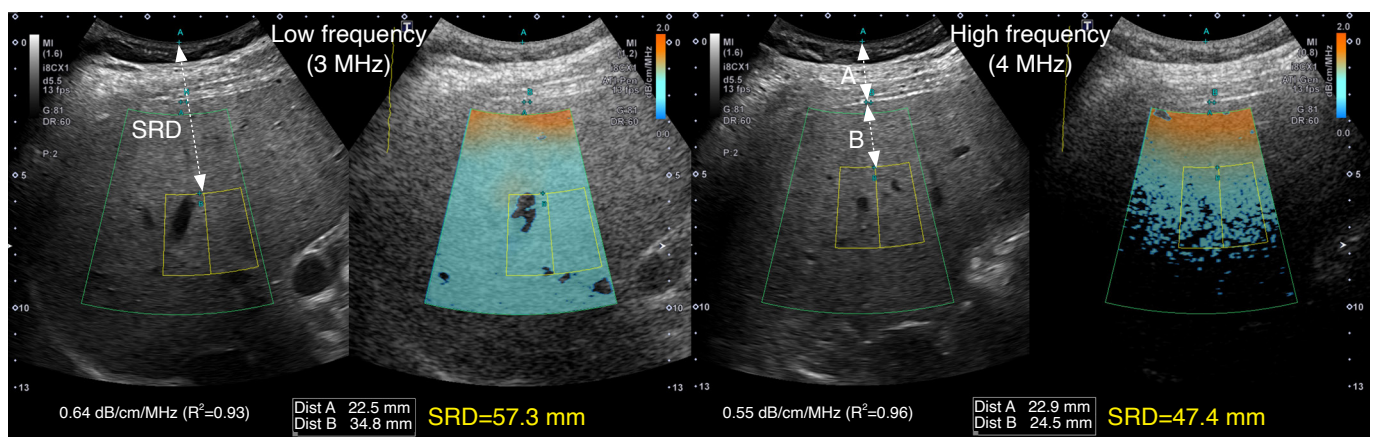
Measurements of attenuation coefficient (AC) using low-frequency and high-frequency attenuation imaging modes in a 29-year-old man with metabolic dysfunction-associated steatotic liver disease. A represents the skin-to-capsule distance, while B indicates the distance from the liver capsule to the region of interest (ROI). The sum of these two distances represents the skin-to-ROI distance (SRD). Despite a greater SRD in the low-frequency mode (57.3 mm) than in the high-frequency mode (47.4 mm), the AC is higher in low-frequency mode (0.64 dB/cm/MHz) than in high-frequency mode (0.55 dB/cm/MHz). All measurements were valid ($R^2 > 0.8$). The patient underwent an ultrasonography-guided liver biopsy for liver donation, with a hepatic fat fraction of 25% being reported on pathology.
